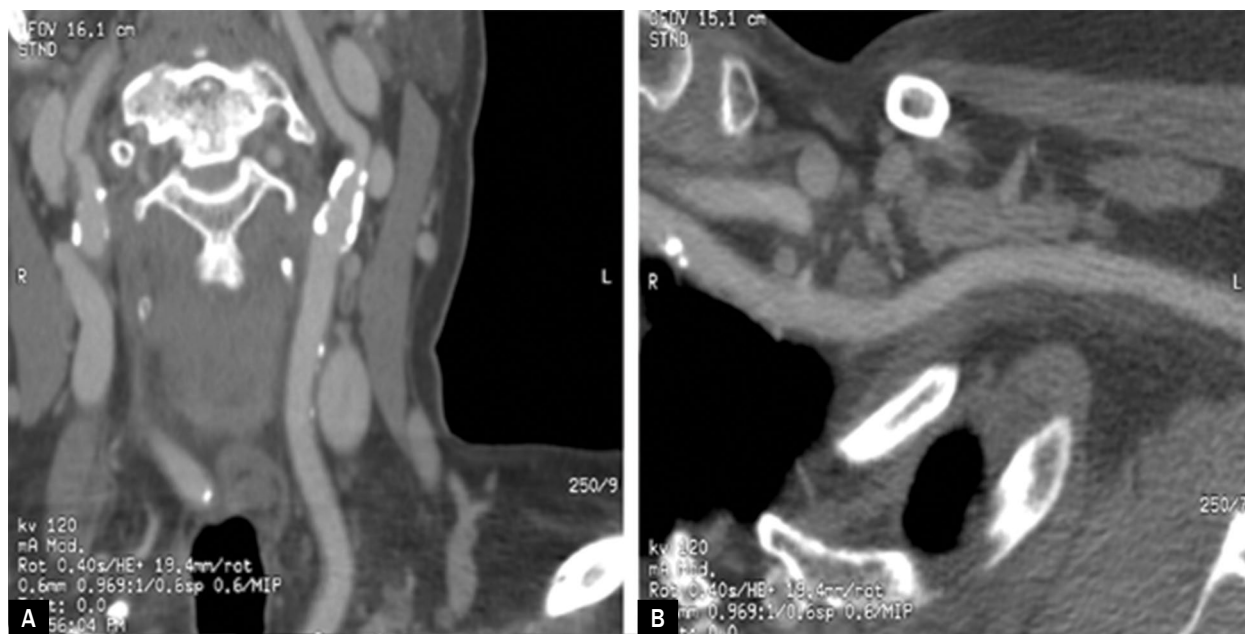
Computed tomography of the arteries of the head and neck – in the left internal carotid artery circular calcified plaque in the bulb
